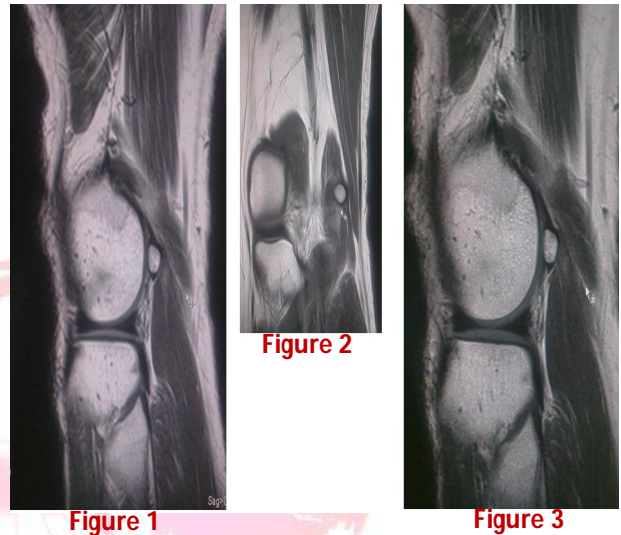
MRI Scan of a Patient with Os Fabella.
